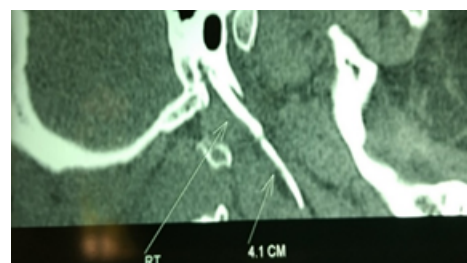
CT Neck lateral view showing the right elongated styloid process.
